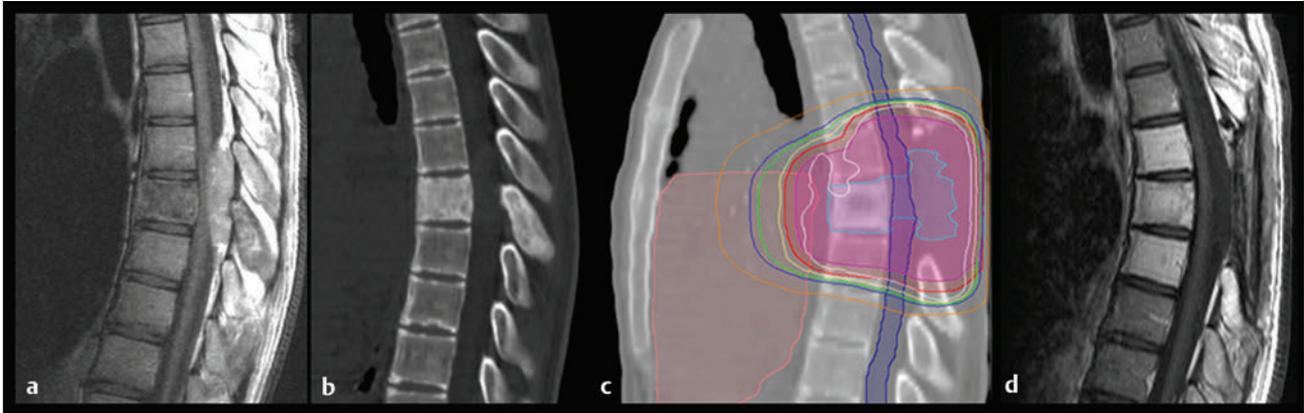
This 16-year-old boy presented with a progressive paraparesis, back pain, and a midthoracic sensory level. He underwent emergent laminectomy for resection of an epidural tumor followed by adjuvant chemotherapy and radiotherapy. Ewing sarcoma. (a) Contrast-enhanced sagittal magnetic resonance (MR) image. (b) Sagittal reconstruction of a computed tomographic (CT) scan. (c) Immediate postoperative CT scan with radiation dosimetry. (d) Follow-up contrast-enhanced sagittal MR image 5 years after surgery. No active tumor is seen. Laminectomy defect and moderate thoracic kyphosis. (Courtesy of Dr. David Harter, Dr. Elizabeth Raetz, and Dr. Ashwatha Narayana.)
